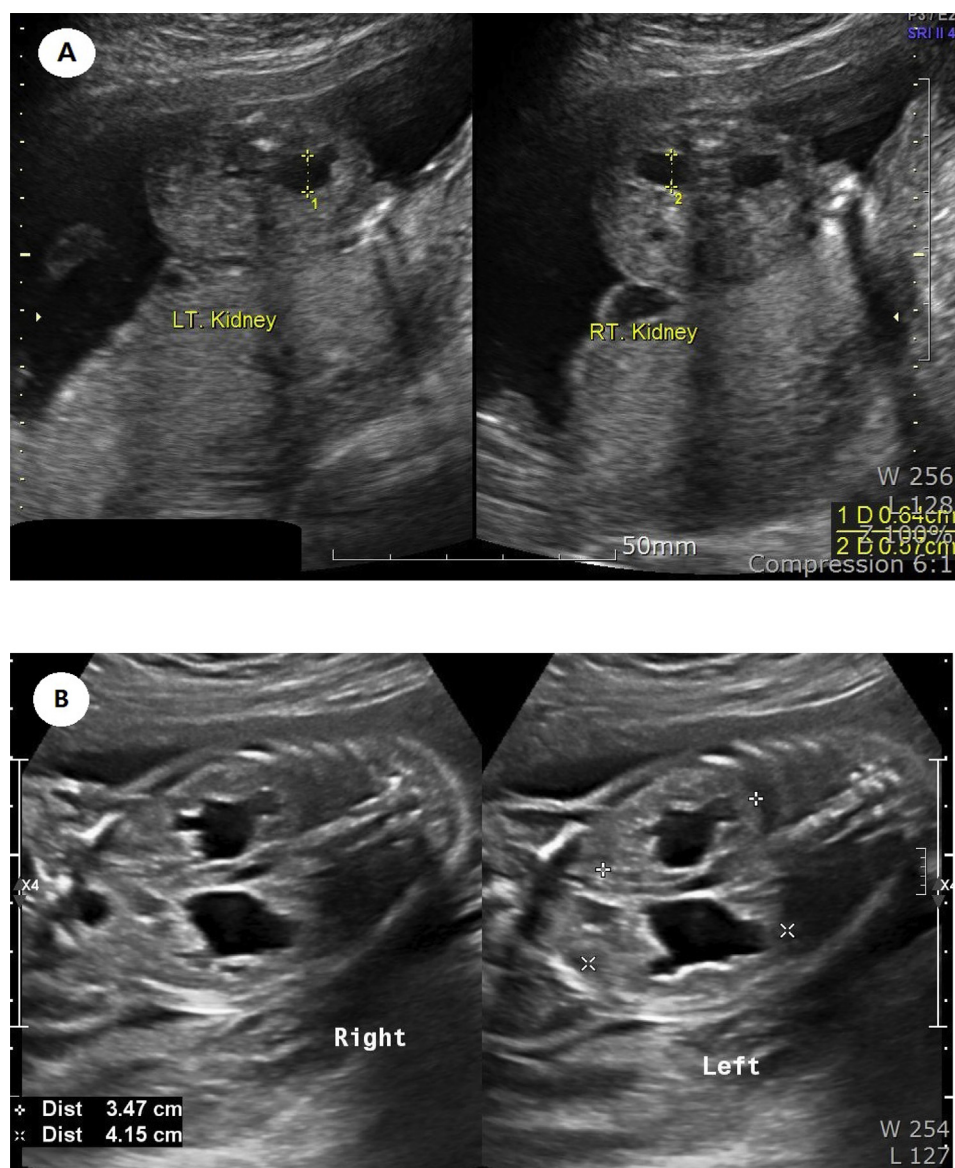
Prenatal ultrasonographic findings of hydronephrosis were A at 17 weeks and 6 days and B at 22 weeks and 5 days.
